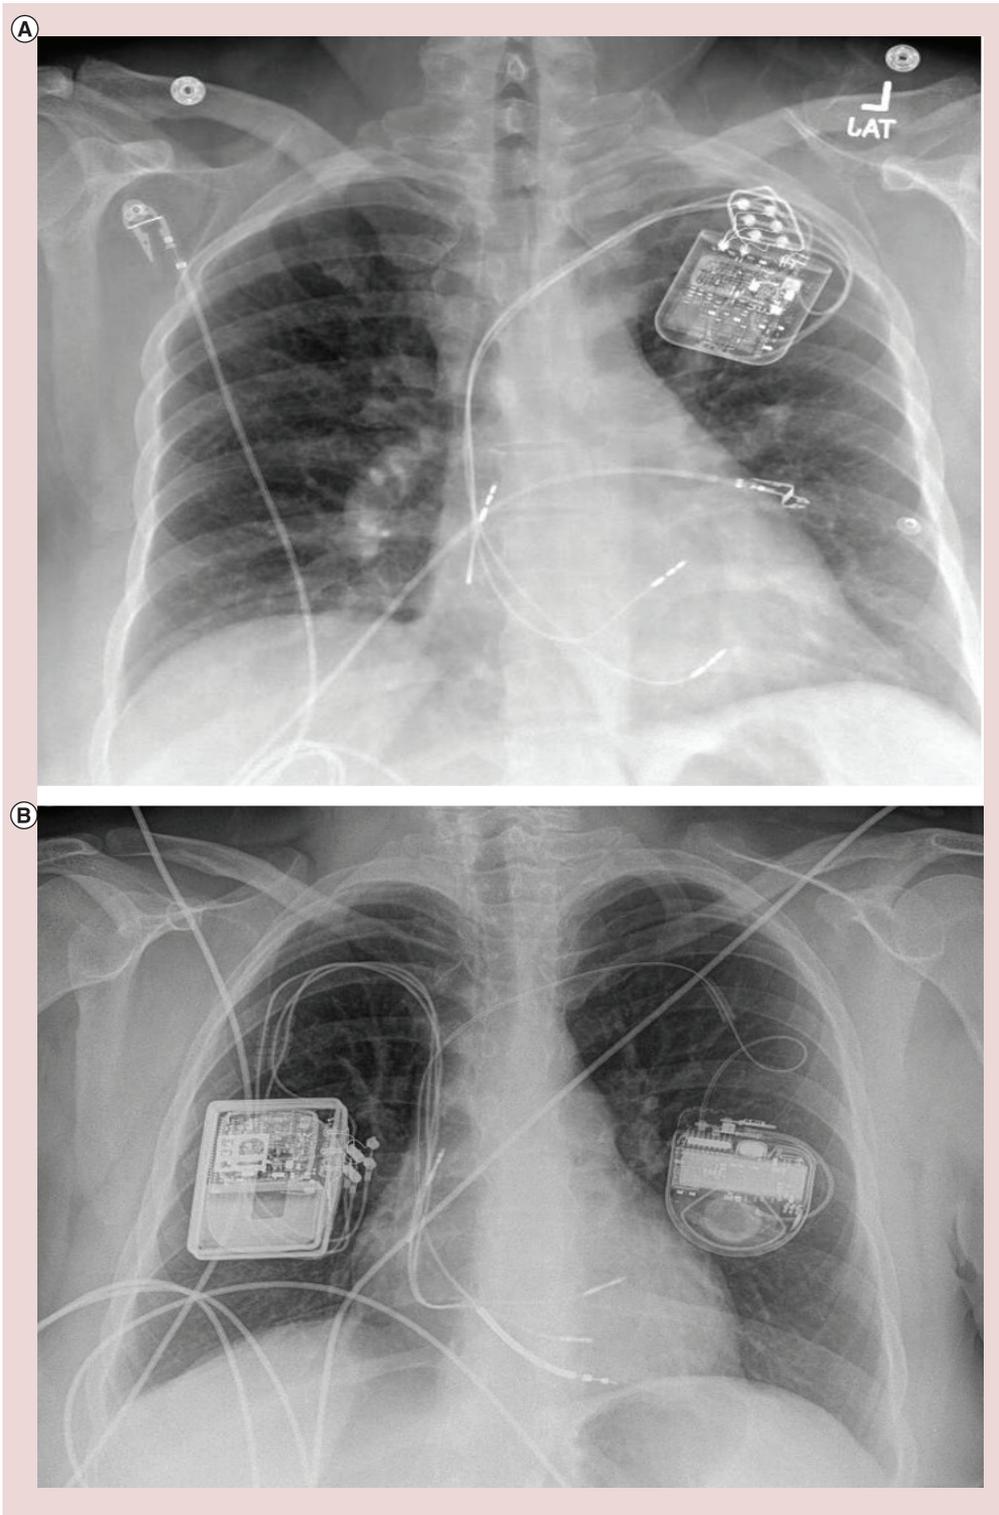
Implanted Optimizer Smart on chest x-ray. Chextradiographs of patient with ejection fraction >35% implanted with Optimizer Smart cardiac contractility modulation device with pulse generator in left pectoral region and three intracardiac leads: one in the right atrium and two in the right ventricle interventricular septum (A) and patient with ejection fraction <35% with implanted Optimize IV cardiac contractility modulation device with pulse generator in right pectoral region and three intracardiac leads: one in the right atrium and two in the right ventricle interventricular septum plus a standard implanted cardiac defibrillation with generator in left pectoral region and single implanted cardiac defibrillation lead in the right ventricle.
